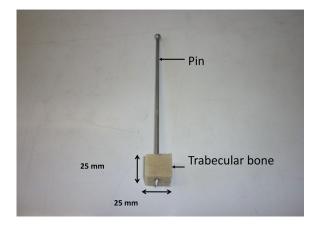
One of the bone samples with the inserted pin used as a reflector for ultrasonic waves.
